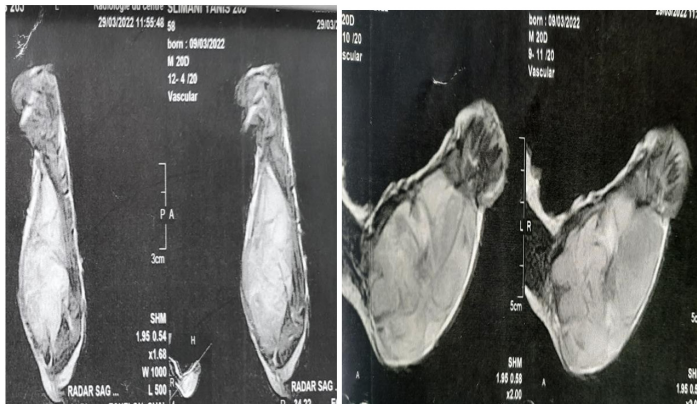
MRI of the infant's left forearm showing a large soft tissue mass suggestive of infantile fibrosarcoma.
